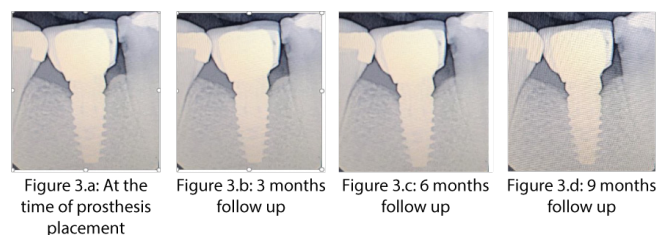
Radiographic status of cement retained implant prosthesis
